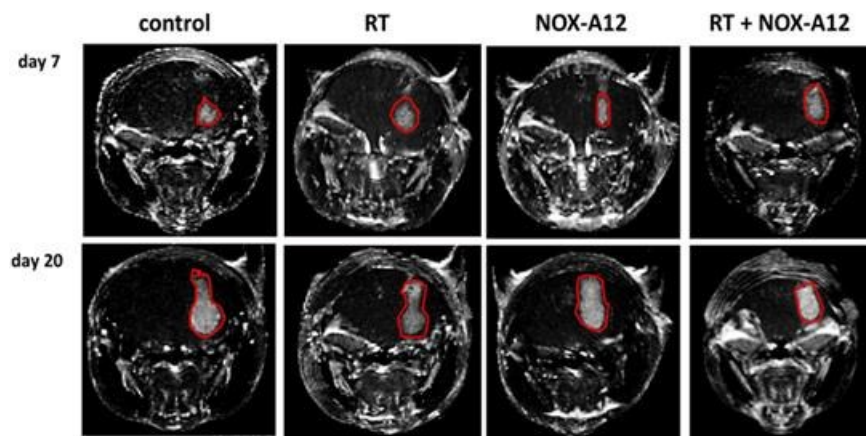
Representative MRI of the analyzed tumors.
